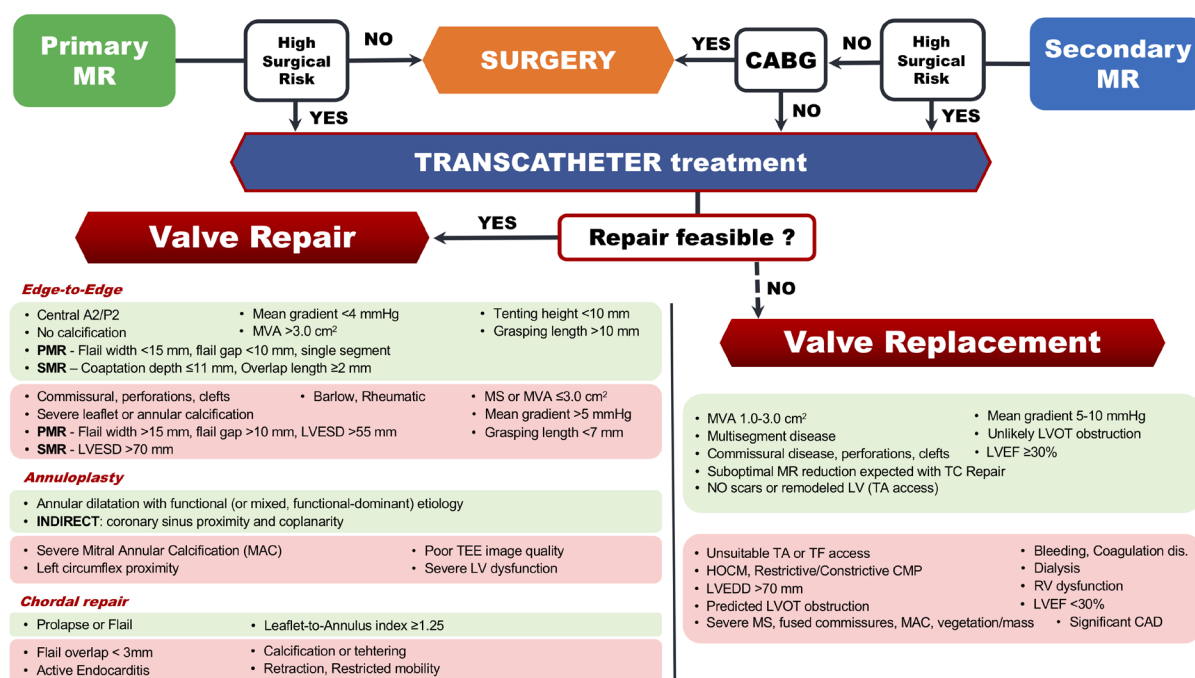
Interventional algorithm for mitral regurgitation. Light green box: favorable feature; light red box: less favorable features or unfeasibility; CABG: coronary artery bypass grafting; CAD: coronary artery disease; CMP: cardiomyopathy; HOCM: hypertrophic obstructive cardiomyopathy; LV: left ventricle; LVEDD: left ventricular end-diastolic diameter; LVEF: left ventricular ejection fraction; LVESD: left ventricular end-systolic diameter; LVOT: left ventricular outflow tract; MS: mitral stenosis; MVA: mitral valve area; PMR: primary mitral regurgitation; RV: right ventricle; SMR: secondary mitral regurgitation; TA: transapical; TC: transcatheter; TEE: transesophageal echocardiography; TF: transfemoral
